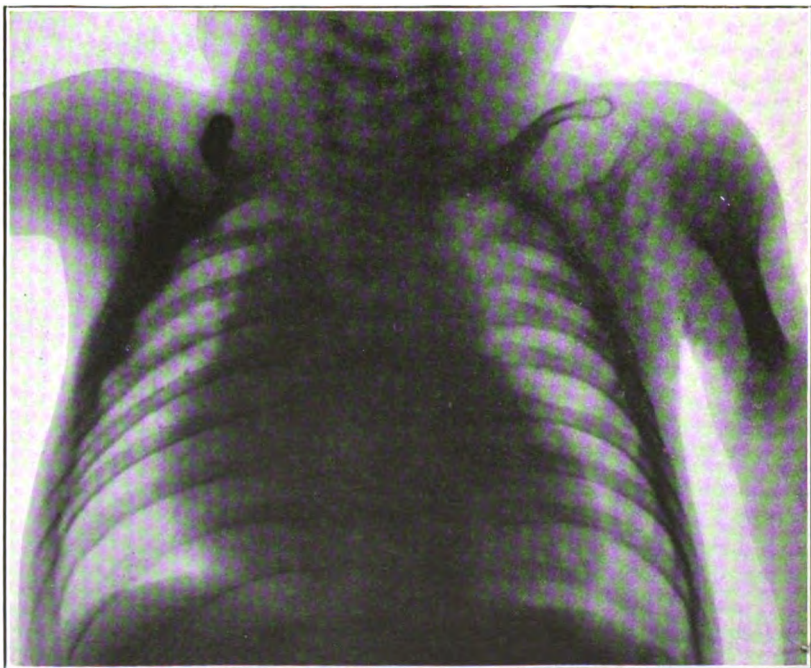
Case of congenital thymus (atrophy of gland following two exposures to roentgen ray).
